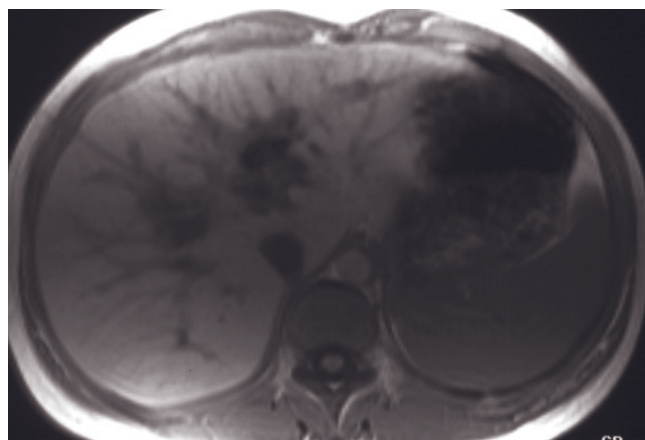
Lymphoproliferative disorder. T2-weighted fat-suppressed ETSE (a) and immediate postgadolinium SGE (b) images. A 3-cm mass is present in the porta hepatis that is moderate in signal on the T2-weighted image (arrows, a) and enhances minimally with gadolinium (b).
